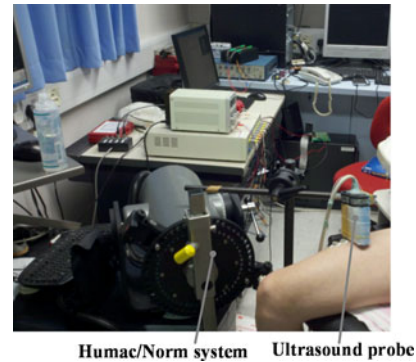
Experimental setup for collecting ultrasound images from the subject's right QM during isometric knee extension. The ultrasound probe was aligned perpendicularly to QM belly using a multidegree adjustable bracket.
